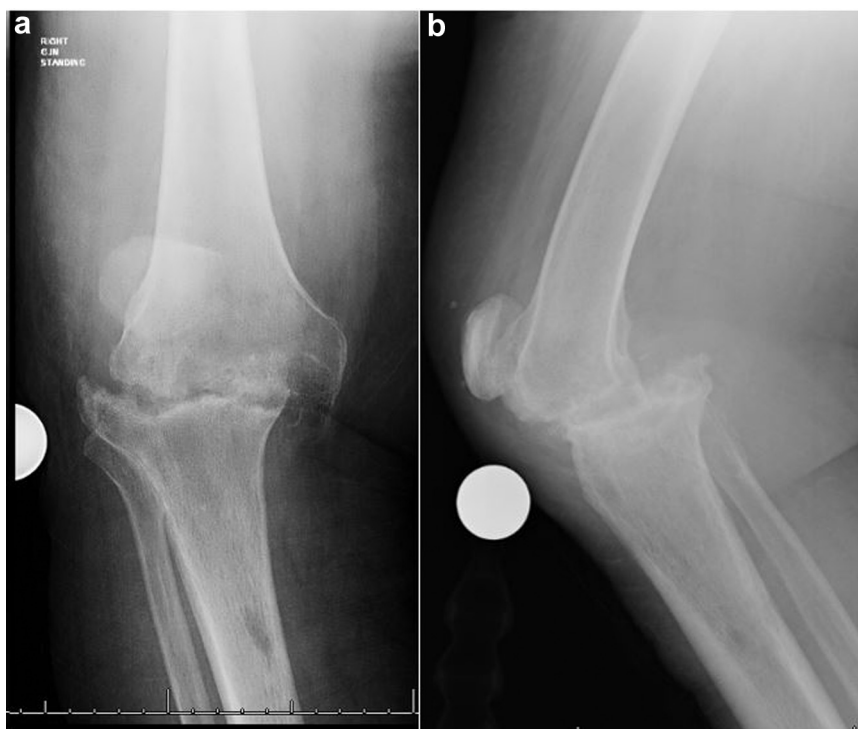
Prearthrodesis radiographs. Anteroposterior (a) and lateral (b) radiographs showing extensive articular surface erosion and bone loss with varus deformity.
